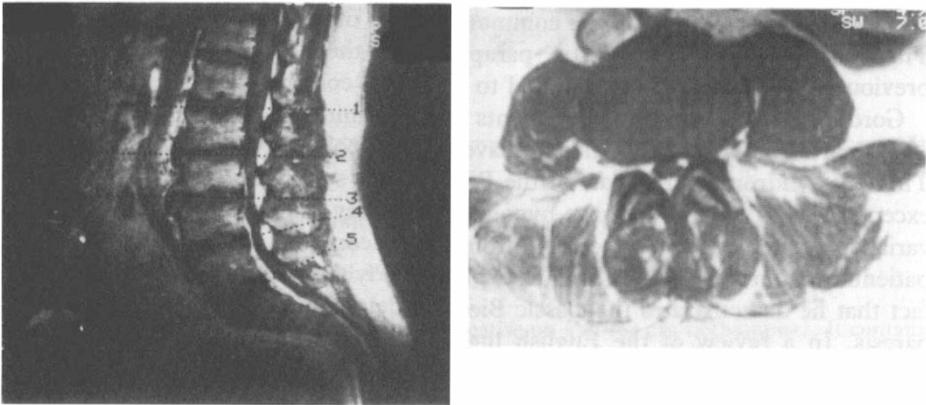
Magnetic resonance imaging of the lumbar spine demonstrating severe spinal stenosis with cord atrophy.
